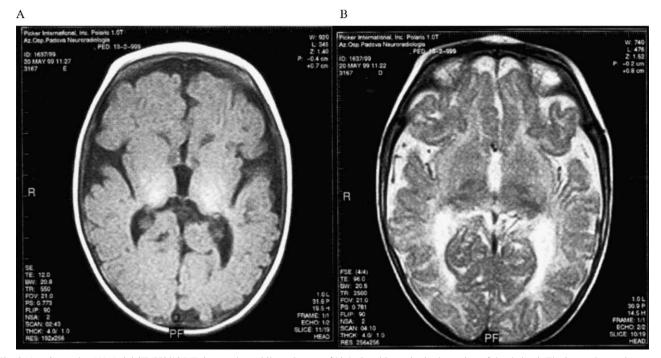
Age 3 months. (A) Axial SE 550/12 MR image shows bilateral areas of high signal intensity in the region of the thalami. The internal capsula appears poorly myelinated. (B) Axial FSE 2500/96 MR image shows slight hyperintensity in the same region.
